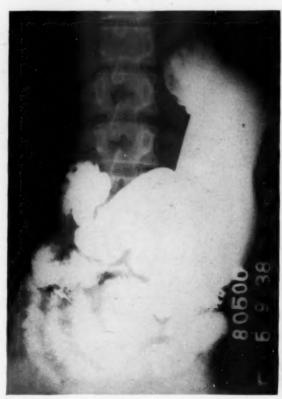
Roentgenogram of stomach one year and two months after operation. The site of the former ulcer defect is smooth.
